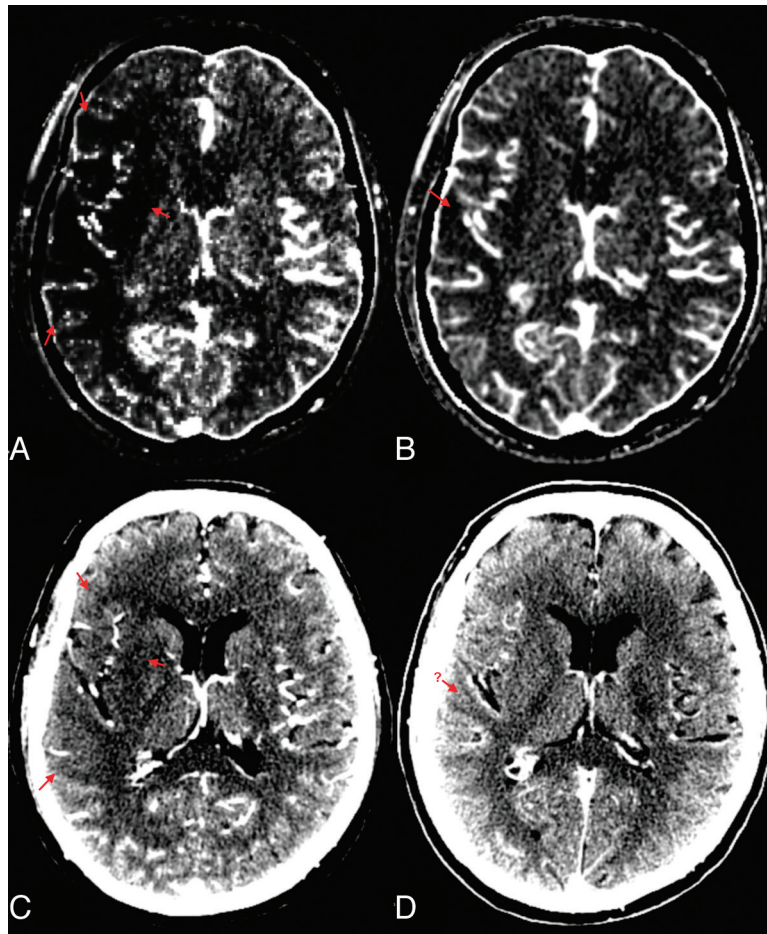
CBF map (A) reveals a large defect within the right MCA territory, while the CBV map (B) shows a substantially smaller region of infarction. C, CTA source image show hypoattenuation and gray-white matter differentiation loss in the right MCA territory corresponding to the CBF defect. D, PCCT image demonstrates subtle questionable posterior Sylvian hypoattenuation.
